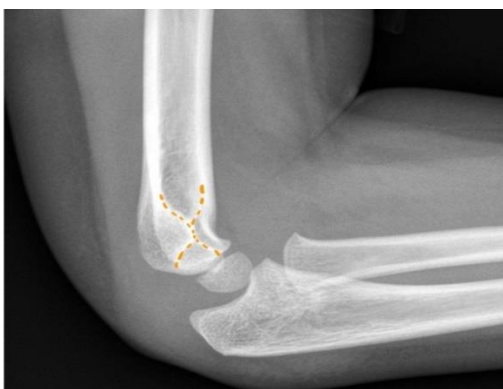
Note the hourglass view in true lateral x-ray of distal humerus
